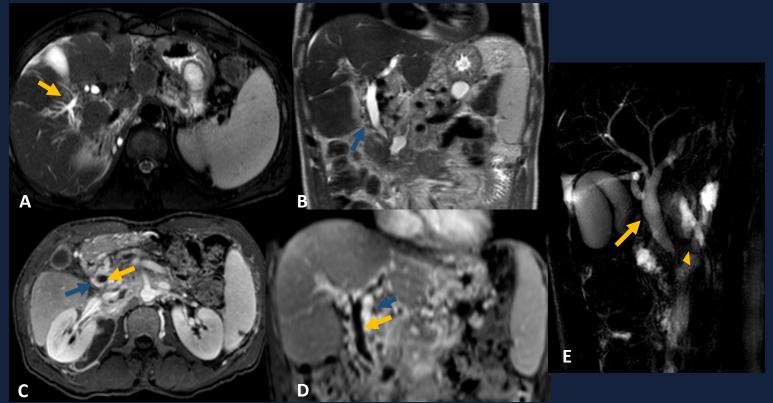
56-year male patient with alcoholic and HCV-related cirrhosis, with a known portal cavernoma. (A) T2-weighted FS axial (B) and T2-weighted coronal MR images, demonstrating intra-hepatic biliary branches (yellow arrow) and common bile duct dilatation (blue arrow). (C) Axial and (D) coronal contrast-enhanced T1-weighted MR images showing a dilated hypointense common bile duct (yellow arrow) surrounded by an enhanced serpiginous portal cavernoma (blue arrow). (E) MRCP image displaying a hole common bile duct dilatation (arrow) and a narrowing at its lower end (arrowhead).
